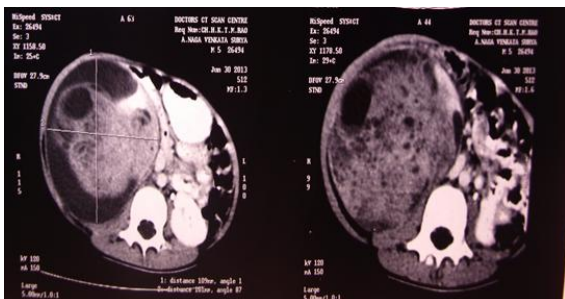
CT Scan – Wilms tumor
